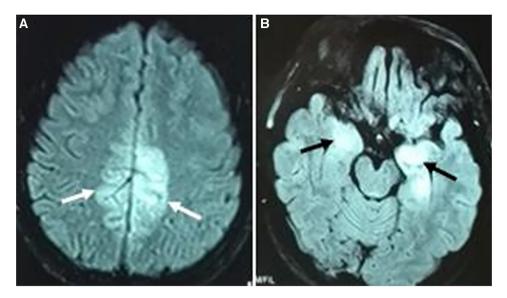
(A/B) Initial T<sub>2</sub>-MRI showing hyerintense lesions in bilateral cingulate gyrus (white arrows) and hippocampus (black arrows).
